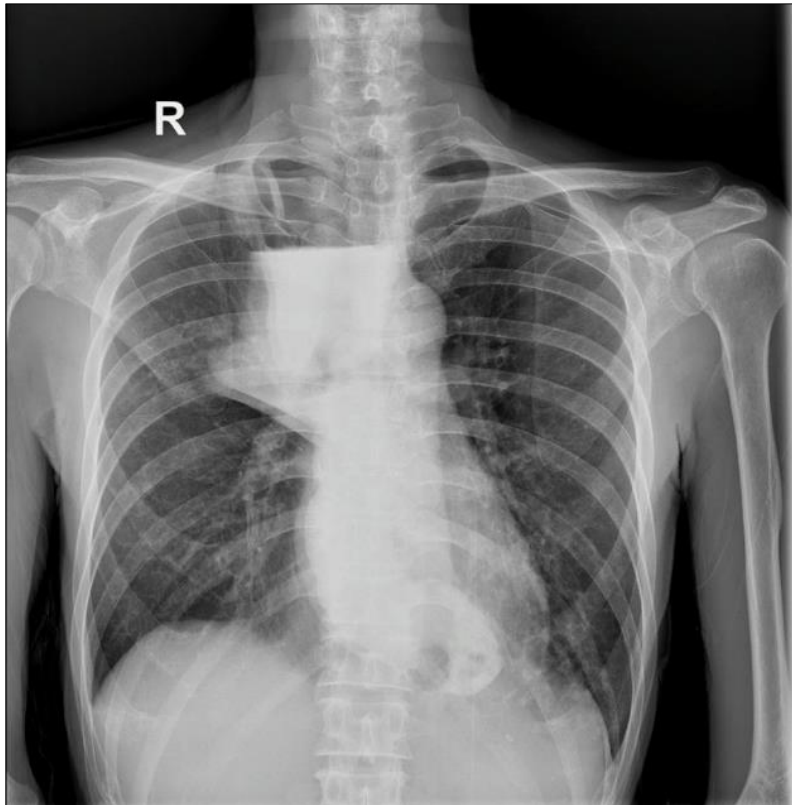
Chest X-ray with contrast, AP Position
